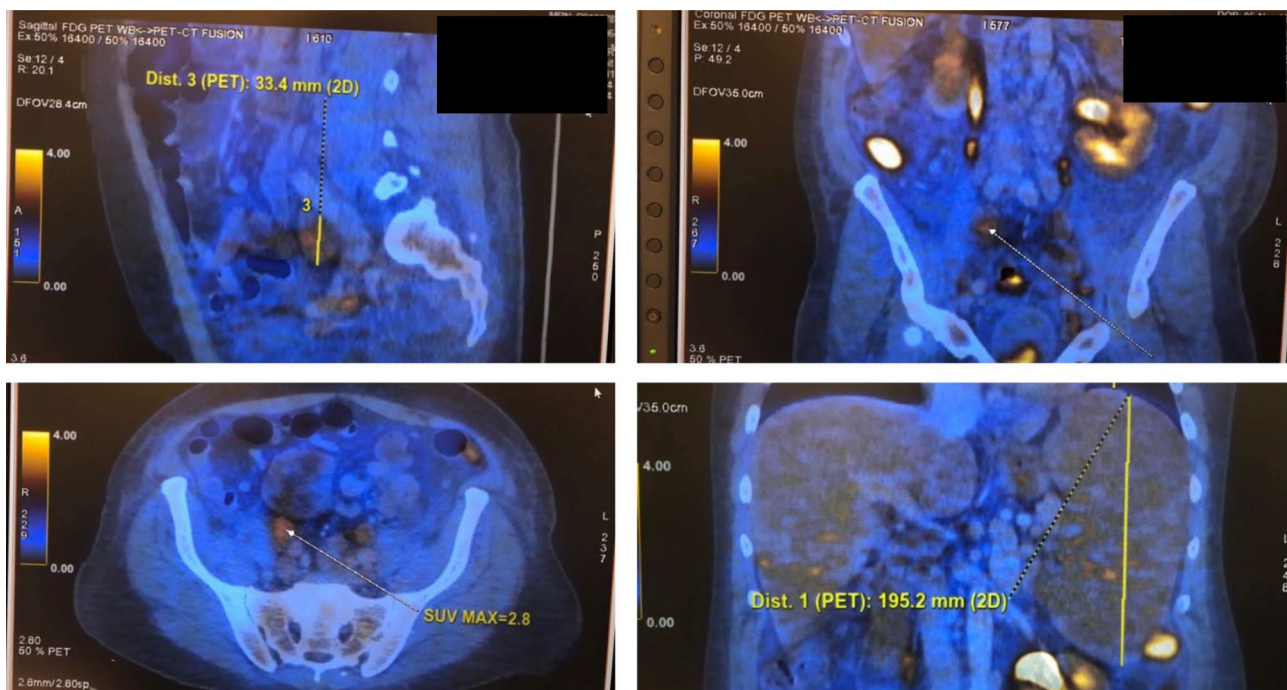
PET-CT findings of the patient
